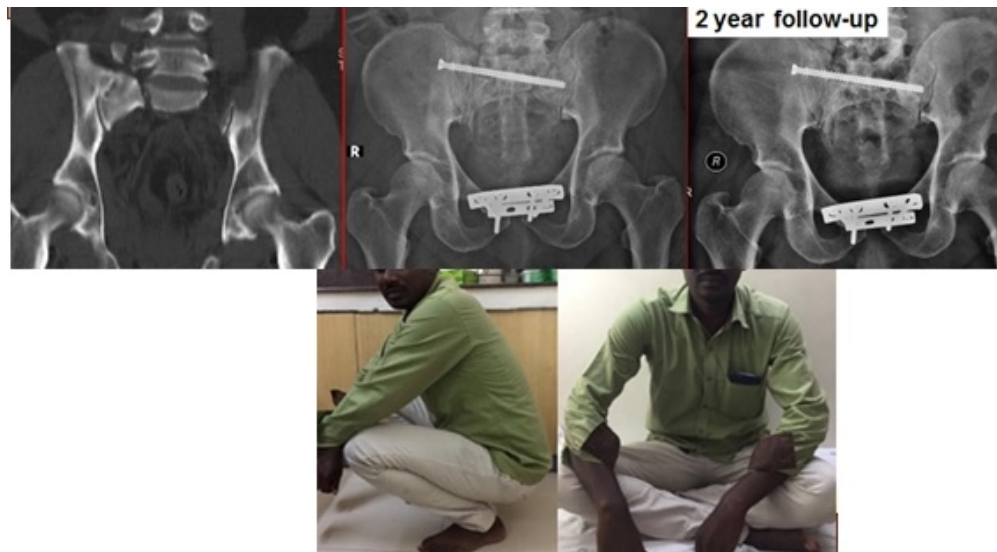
Pre-operative CT-scan and post-operative AP radiographs and clinical photographs of a 32-year-old male showing vertical shear injury with spino-pelvic dissociation (L5 Transverse process fracture) managed by SI-screw alone with good radiographic and functional outcome at 2 year follow-up. Anterior stabilization was done by dual-plating of symphysis pubis.
